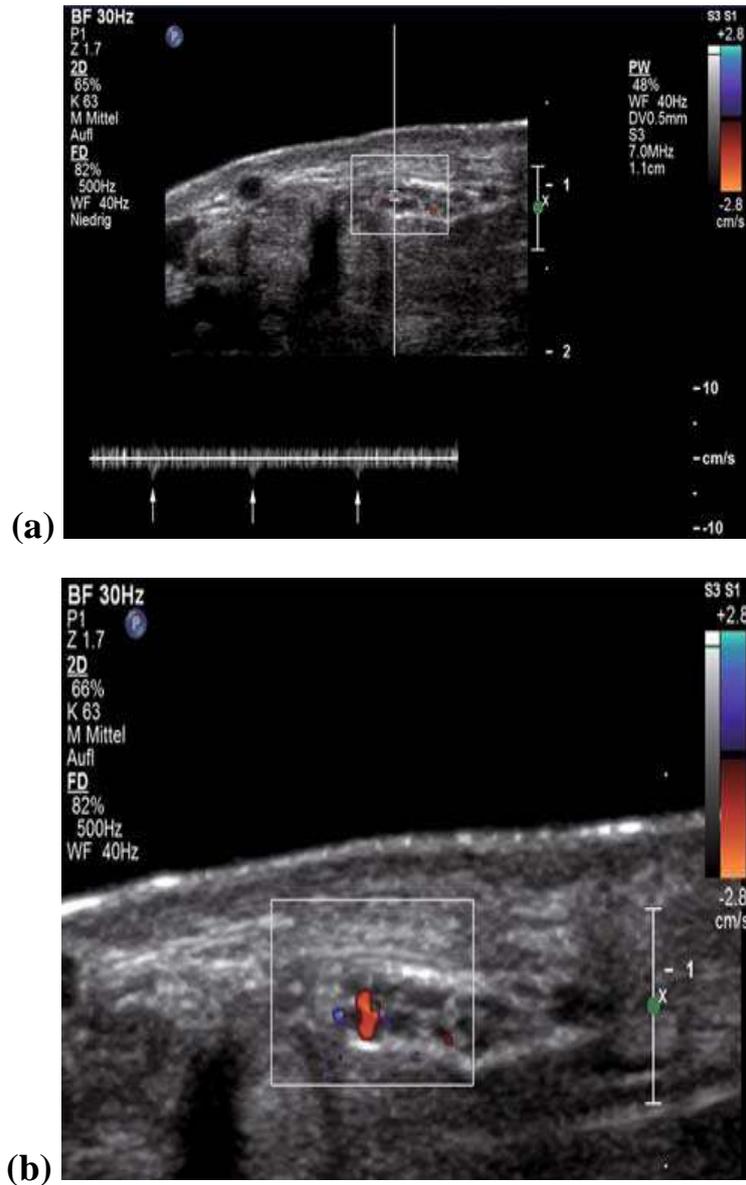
a,b): Transverse US scan of the median nerve at the wrist using Color Doppler US (a) to depict feeding vessels (vasa nervorum), which are small in size and show low, arterial flow in pulsed wave Doppler (arrows) (b) (*Quoted from Baert et al., 2008*).
